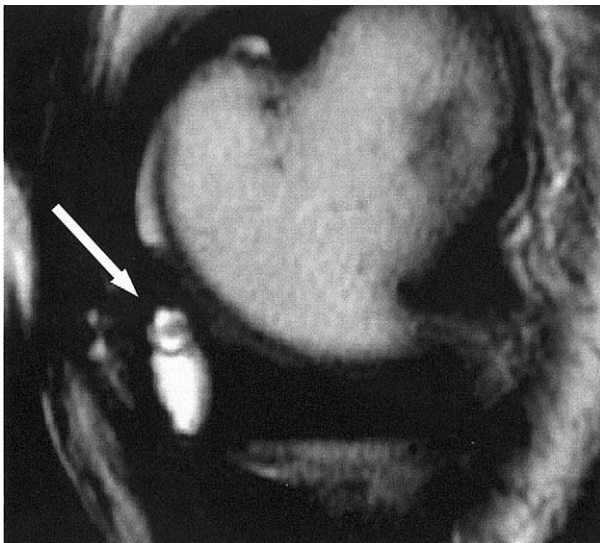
Magnetic resonance imaging shows the BioStinger (arrow) located posterior to the meniscus and parallel to it. The circle is the BioStinger cross piece and the dot in the center is the shaft.
